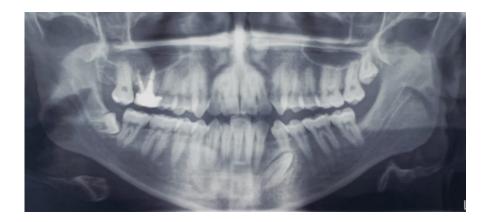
Initial radiographic features of the patient with maxillary atresia.
